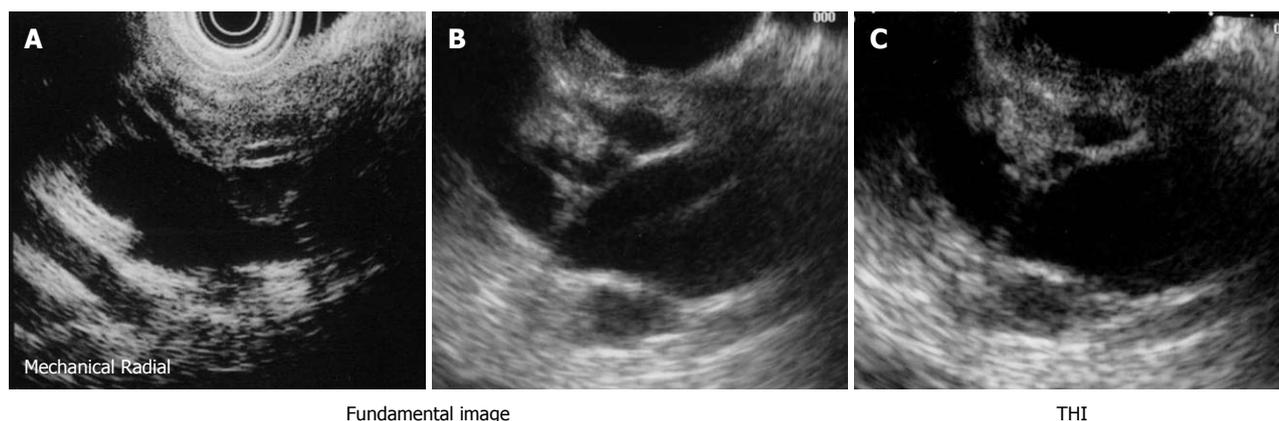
Branch-duct type intraductal papillary mucinous neoplasm. A: An mechanical radial scanning endoscopic ultrasonography (EUS) image could not depict the mural nodule due to a near field artifact; B, C: Electronic radial scanning EUS images revealed a mural nodule about 10 mm in diameter; C: The image was made more sophisticated by tissue harmonic imaging (THI) technology, which brought a clearer ultrasonographic image by omitting acoustic artifacts.
